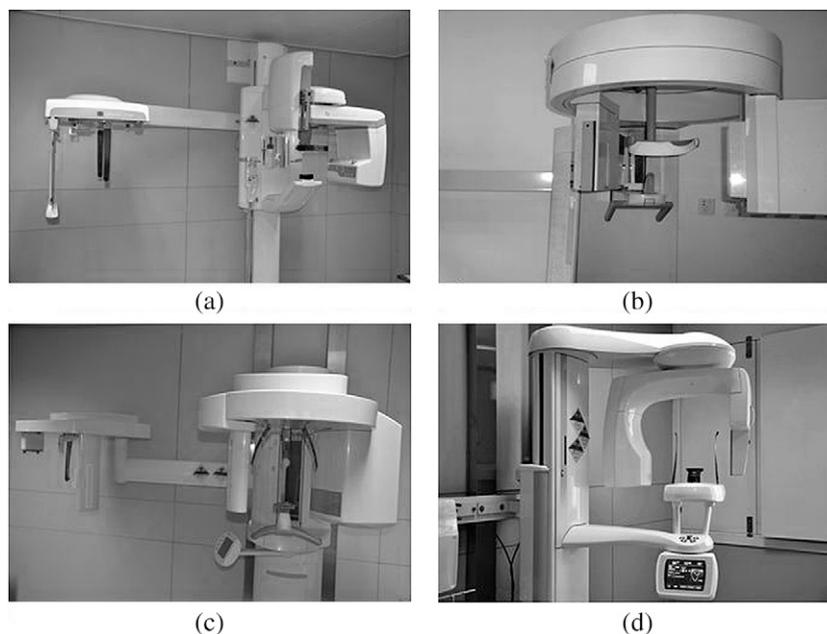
Images of the four panoramic machines (a) Orthopantomograph® OP200 (Instrumentarium Dental, Tuusula, Finland), (b) Orthophos CD (Sirona Dental Systems GmbH, Bensheim, Germany), (c) Orthophos XG Plus (Sirona Dental Systems GmbH) and (d) ProMax® (Planmeca Oy, Helsinki, Finland)
